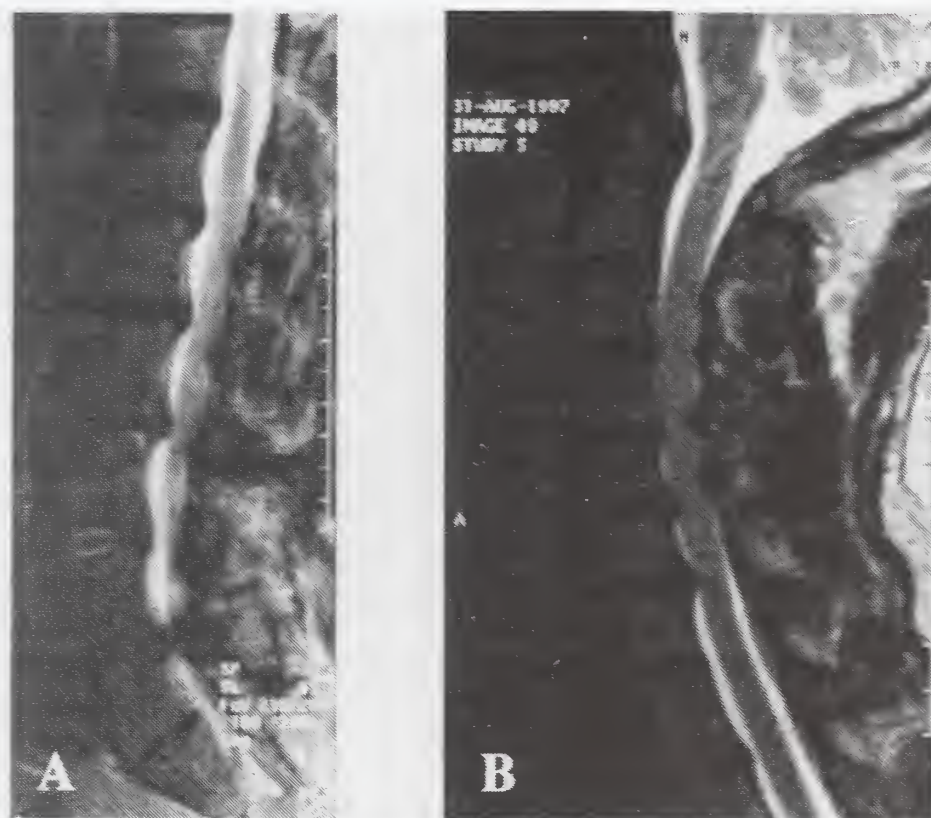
Tandem stenosis, T2-weighted MRI, sagittal view. The severe cervical spinal stenosis (B) resulted in myelopathy and required correction through a multilevel cervical laminectomy before the patient's more painful lumbar spinal stenosis (A) could be surgically addressed.
